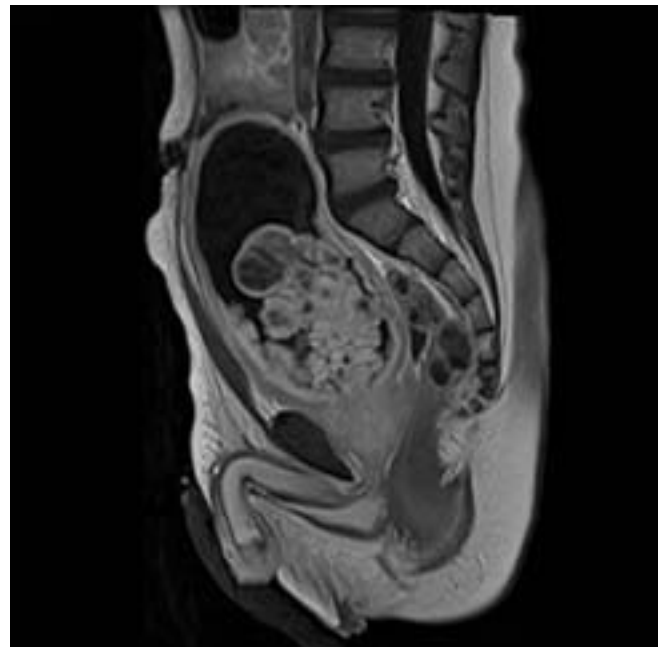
Patient 2: The MRI examination of the abdomen and pelvis at diagnosis. A T1-weighted sagittal image – huge pathological solid mass measuring $62 \times 45 \times 46$ mm, filling 2/3 of the bladder lumen.
